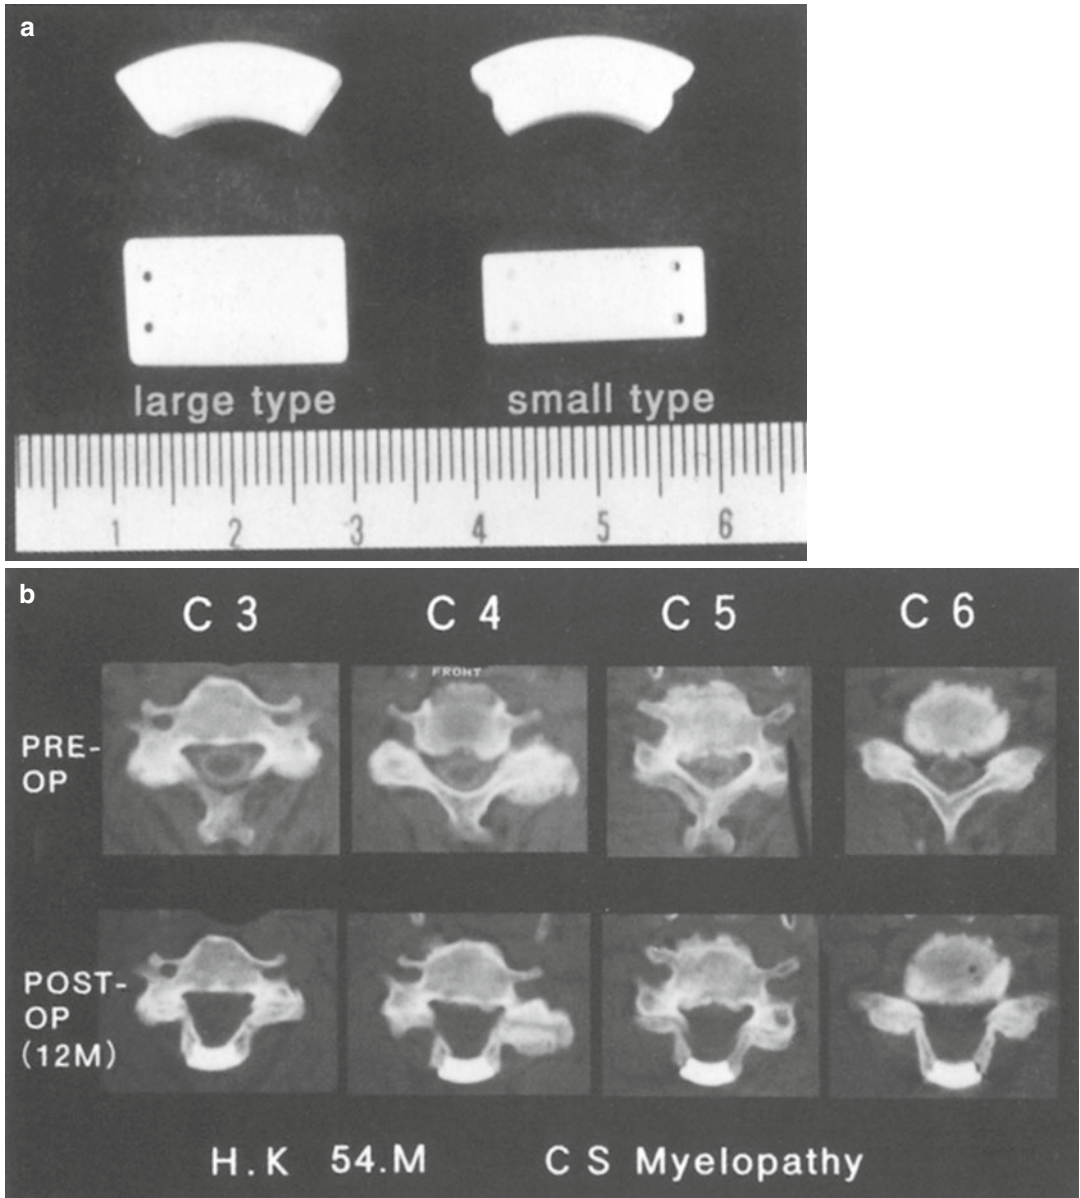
(a) Laminoplasty spacers made of AW-GC. (b) CT images of a 54 year old male suffering from cervical myelopathy due to spondylosis (*upper row*). Enlargement and reconstruction of the spinal canal was performed by the use of laminoplasty spacers in four levels (*lower row*)
